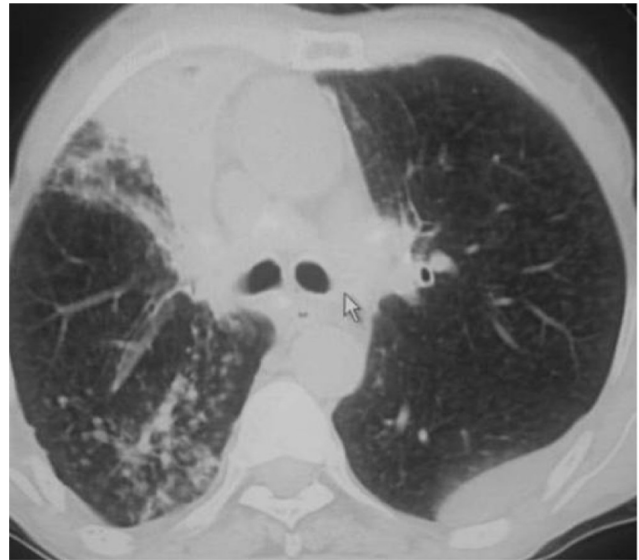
CT scan chest showing pleuro-pulmonic disease with direct extension to right anterior chest wall.
